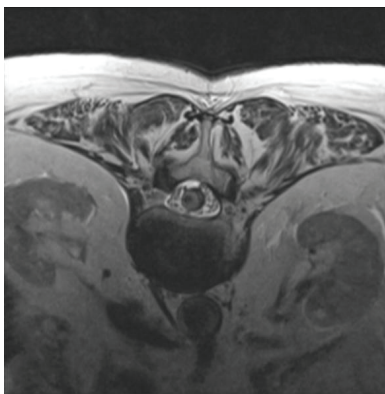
Cone Cavernome Hemorrhage at Axial Spine T2 MRI.
